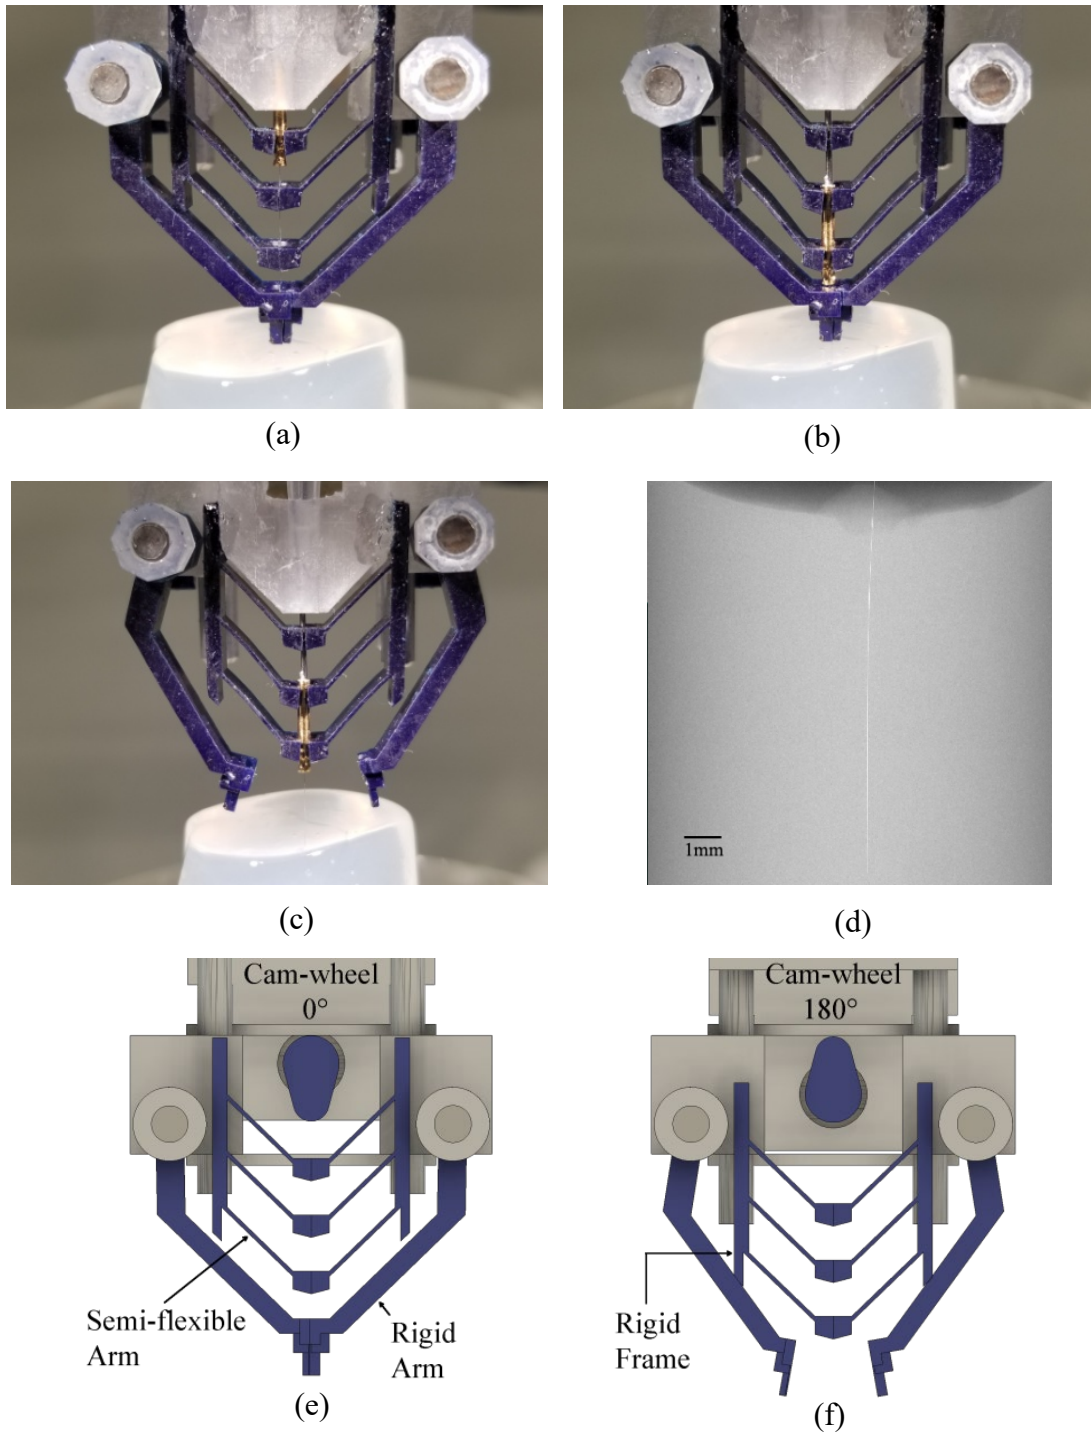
Demonstration of the electrode guide. The state of the guide and the position of the electrode - (a) before and (b) after insertion. The semi-flexible arms open up one by one as the electrode socket pushes them downward. (c) Opening of the rigid arms after insertion. (d) CT image of the inserted electrode in agar gel. The electrode appears as a thin white line in the image. (e) 0° position of the cam-wheel when rigid arms are closed. (f) 180° position of cam-wheel to retract and open the rigid arms. © [2019] IEEE Reprinted with permission from [57]
